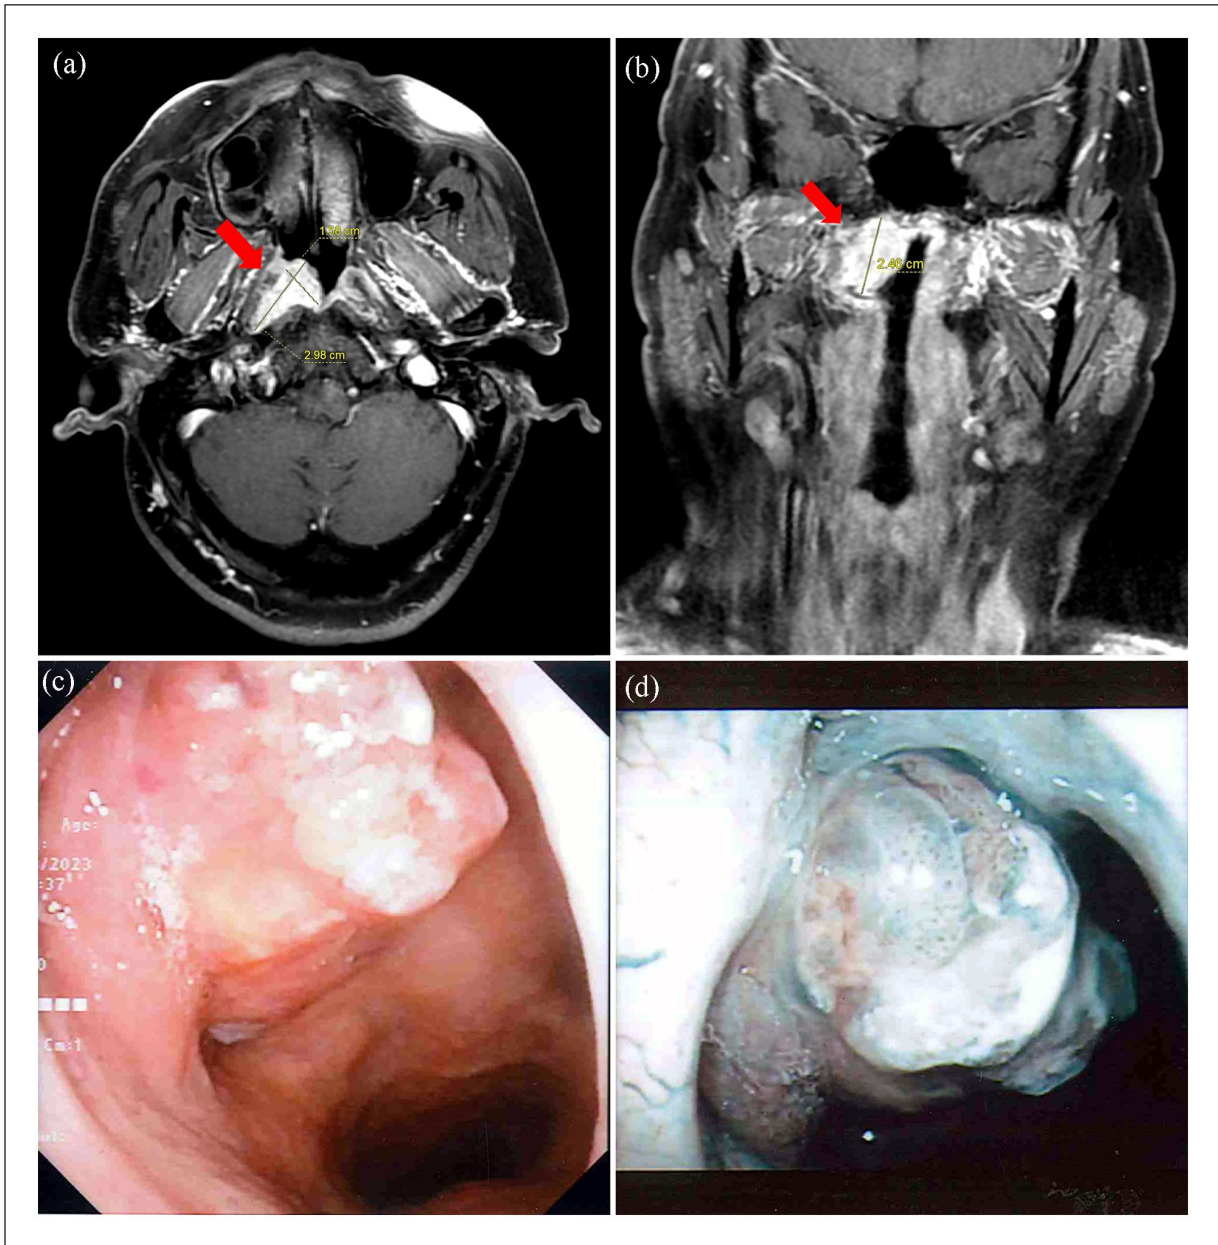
Magnetic resonance imaging revealed a 3 cm contrast enhancing mass (red arrow) in the right wall of nasopharynx and extended to the right lateral pharyngeal recess of the nasopharynx ((a) Axial view. (b) Coronal view). Endoscopic examination found an irregularly surfaced fragile mass in the right lateral wall of nasopharynx (c). Narrow band imaging revealed multiple dilated and irregular caliber of intra-epithelial papillary capillary loops on the surface (d).
